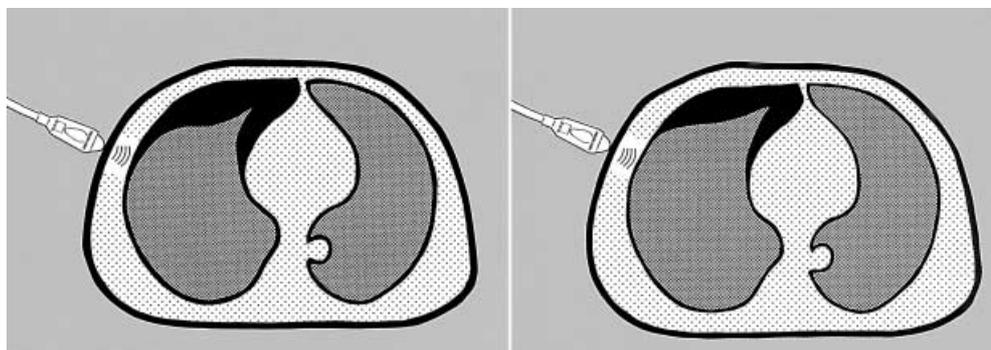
A theoretical explanation of the “lung point”. *Left:* at expiration, the pneumothorax has a defined volume on CT. A probe placed at a point slightly superior to the lung level will display a pneumothorax pattern. *Right:* at inspiration, the lung volume should slightly increase, therefore increasing the surface of the lung in contact with the wall. The probe remaining at the same location will thus display a fleeting pattern of lung, i.e. lung sliding and/or “B lines”
